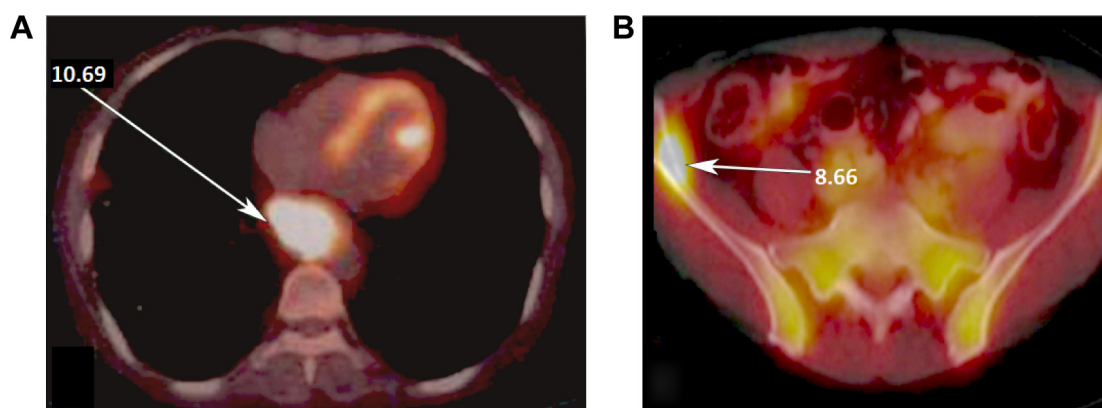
(A) PET scan images showing FDG avid well-defined soft tissue mass seen in the esophagus extending from the subcarinal region till the lower esophagus with the SUVmax value of 10.69 (white arrow) suggestive of malignant lesion. (B) Hypermetabolic lesion in the right iliac crest with the SUVmax value of 8.66 suggestive of skeletal metastatic involvement (white arrow) is seen.
